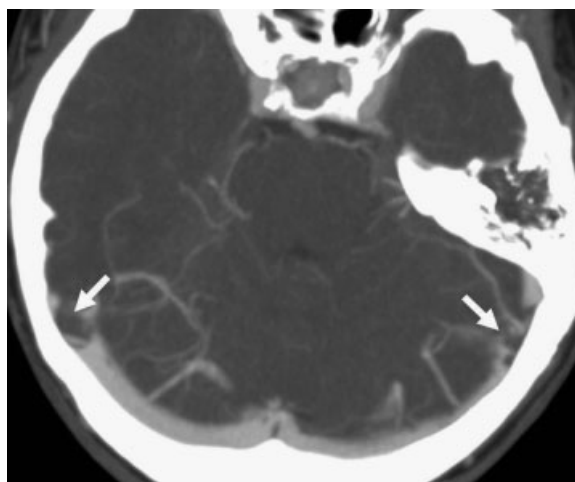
Axial computed tomographic venogram. This shows narrowing at the anterior ends of both transverse sinuses (arrows).
